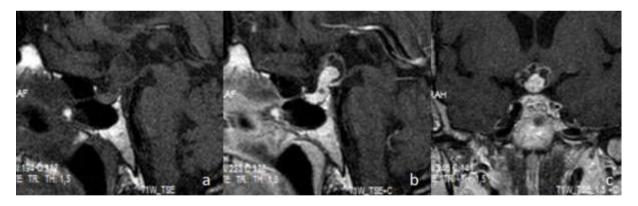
(a-c). Sagittal non-contrast T1-weighted MRI shows heterogeneous suprasellar mass lesion (a). Contrastenhanced solid lesion of stalk with superior cystic-necrotic component demonstrates on contrast enhanced T1weighted sagittal (b) and coronal (c) images.
